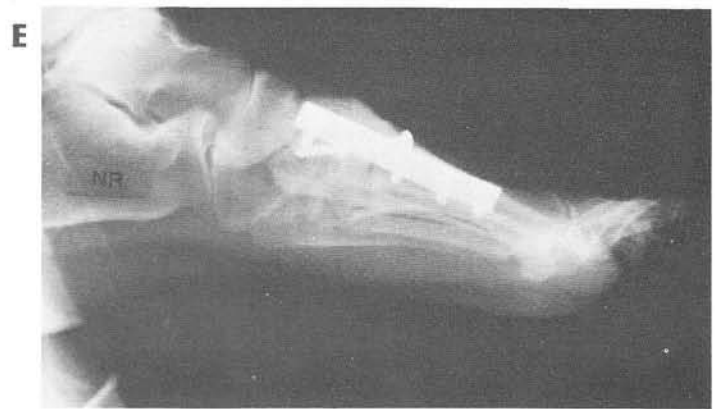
E. Postoperative lateral radiography.
